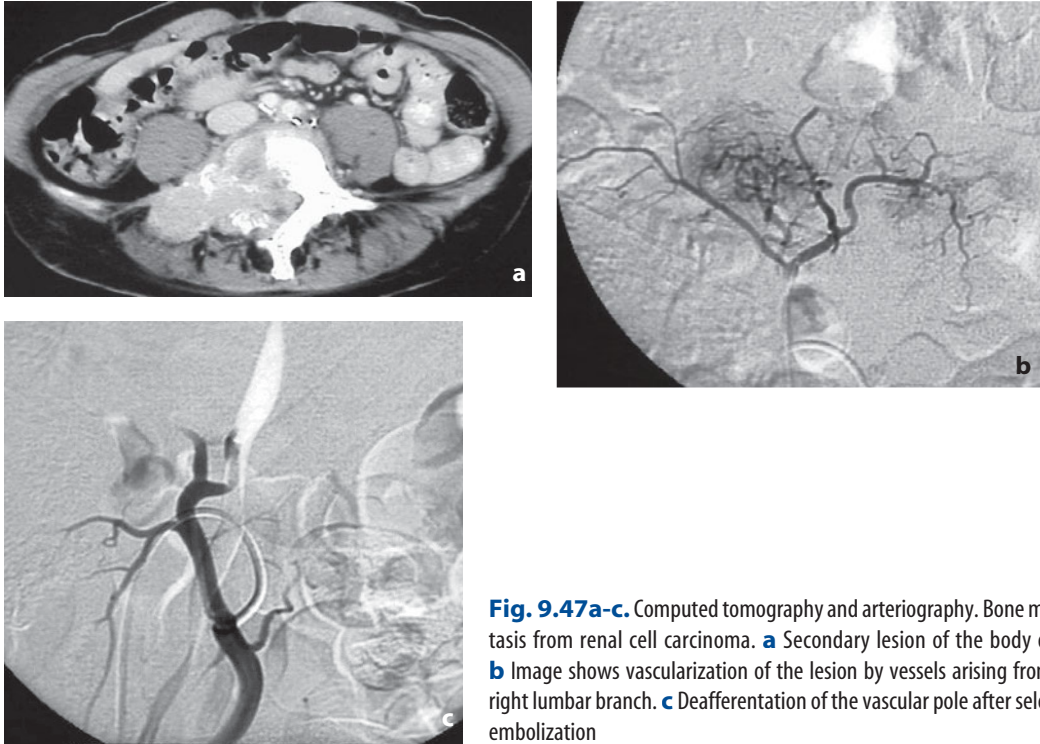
Computed tomography and arteriography. Bone metastasis from renal cell carcinoma. a Secondary lesion of the body of L5. b Image shows vascularization of the lesion by vessels arising from the right lumbar branch. c Deafferentation of the vascular pole after selective embolization
